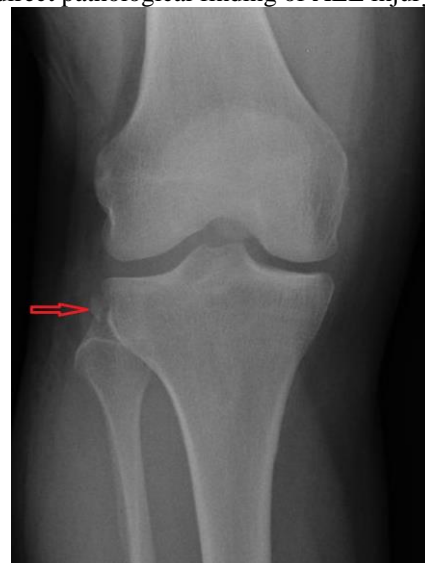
Segond fracture is avulsion fracture of proximal tibia and it is pathognomonic for ACL ruptures and can be seen in direct X-rays
